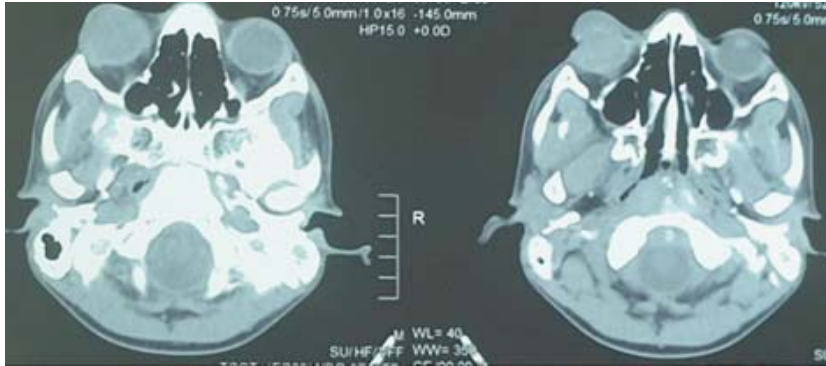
CT scan objectified an exophytic intraocular mass, causing deformation of the right eyeball, with no calcifications.
